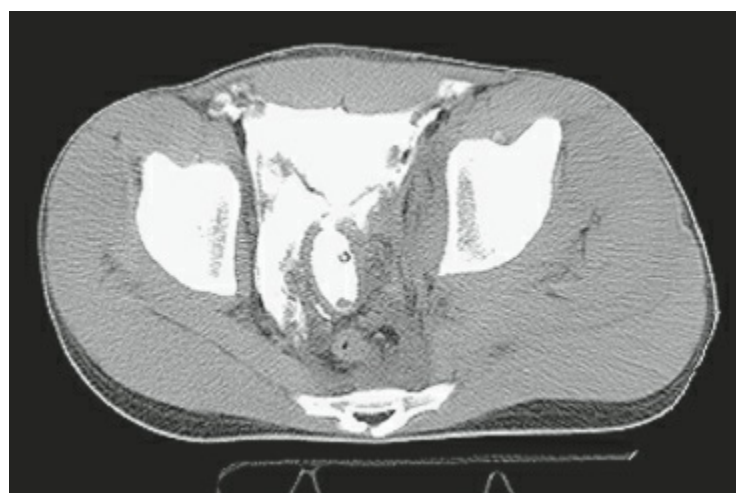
CT cystography for extraperitoneal bladder injury.
